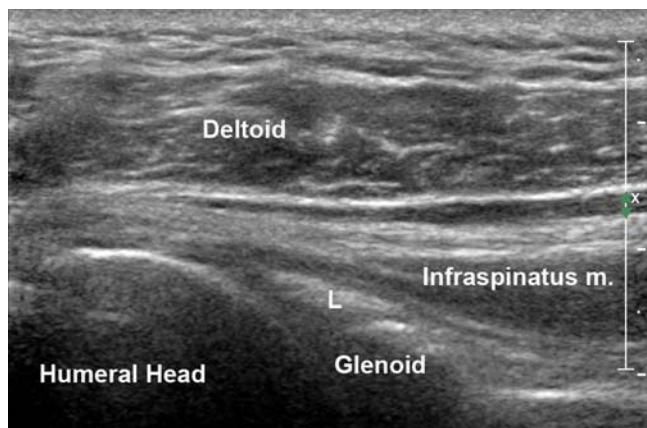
Ultrasound image of the right shoulder glenohumeral joint as viewed from the posterior aspect. L, labrum.*
